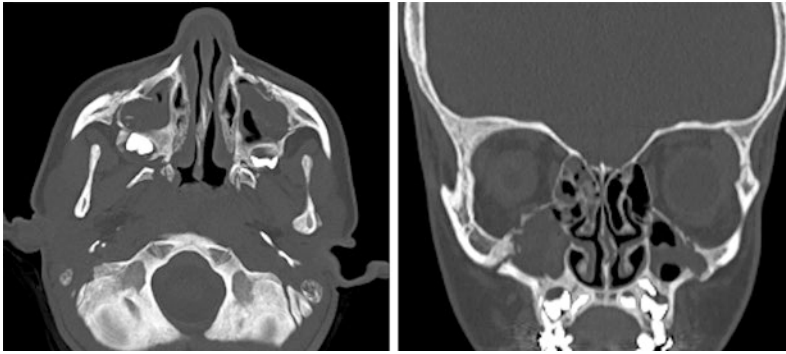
Mid face Le Fort fracture. a Axial and b coronal reformatted CT images (bone window) demonstrate fracture of both pterygoid plates, with bilateral fractures of inferior orbital walls and infero-lateral maxillary sinuses walls
